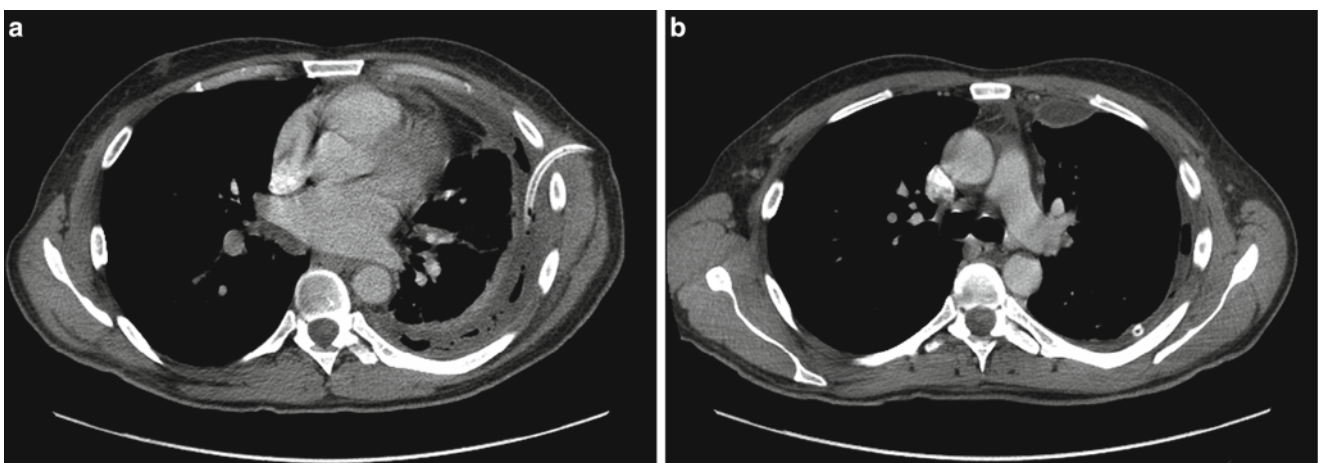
Contrast-enhanced CT scan images of an empyema, following initial insertion of a 16-Fr chest tube by Seldinger technique (a). There is thickening and enhancement of both the visceral and parietal pleural surfaces (split-pleura sign, b)
